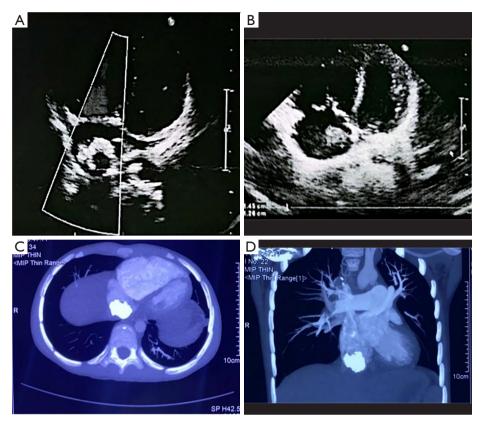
There was a hyperechoic mass with a size of 24.9 mm  $\times$  7.7 mm where the inferior vena cava entered the right atrium, and a hypoechoic mass with a size of 15.5 mm  $\times$  12.6 mm on the right atrial side of the fossa ovale, which seemed to be connected with the fossa ovale by a pedicle. (A,B) Echocardiogram. (C) Cardiac-enhanced CT. (D) Cardiac MIP. MIP, maximum intensity projection; R, right; CT, computed tomography.
